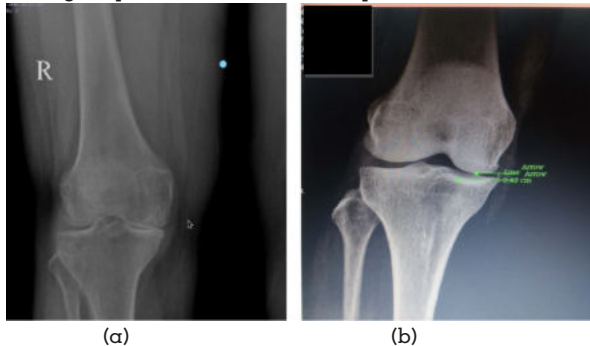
(a) Pre-operative X-ray showing AP view of radiographs right knee joint with reduced medial knee joint space; (b) Post-operative X-ray showing AP radiograph of knee joint after PFO showing increased medial joint space.
